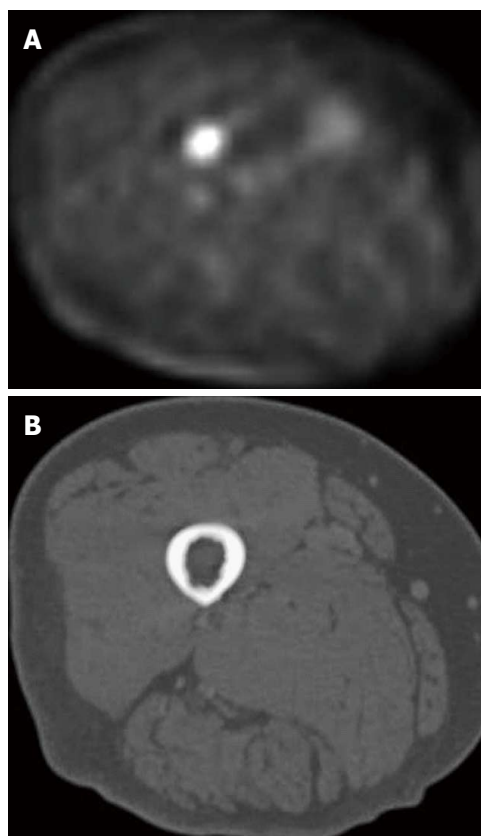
Positron emission tomography-computed tomography. A: Axial PET image of the proximal right femur, showing increased uptake of F-18 FDG; B: Corresponding CT with morphologically normal proximal right femur. PET-CT: Positron emission tomography-computed tomography.
